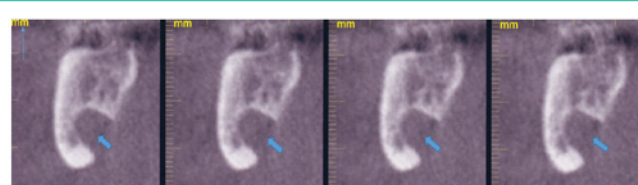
Lingual cortical concavity of the mandible (arrow head) observed with sagittal views of cone beam CT scan consistent with Stafne's bone cavity.
